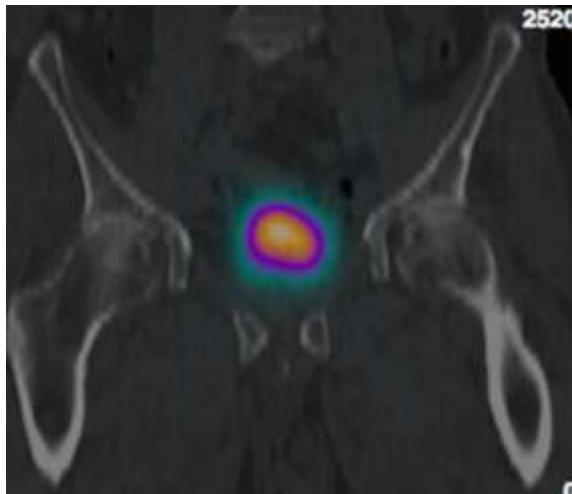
Distribution of ^{213}Bi -anti-EGFR MAb after intravesical instillation visualized via SPECT/CT imaging: all activity remains in the urinary bladder.
